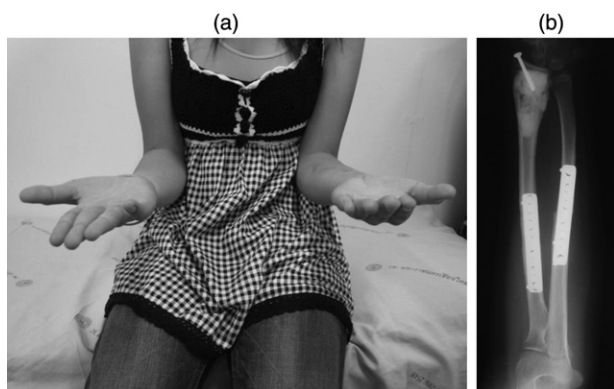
Patient no. 17. (a) Photograph showing 1-year post-operative function of a 14-year-old girl with an osteosarcoma at the left distal radius after osteotomy at the shaft of the radius and ulna and wide resection and extracorporeal irradiation and re-implantation of distal radius. (b) Post-operative forearm radiograph after 24 months showing the union of the radius and ulna after being fixed with small dynamic compression plate and screws.
